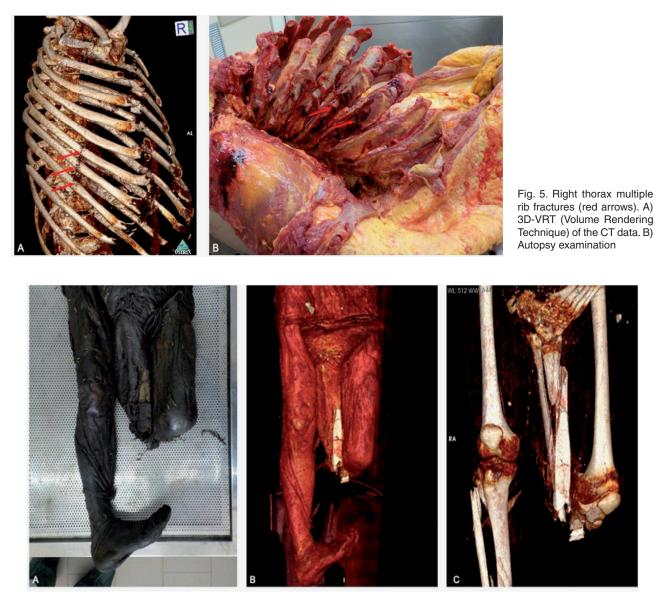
(A) External examination and (B) 3D-VRT (Volume Rendering Technique) of the CT data: view of the body with dislocation of the left leg. (C) 3D-VRT: comminuted fracture of tibia and fibula.
